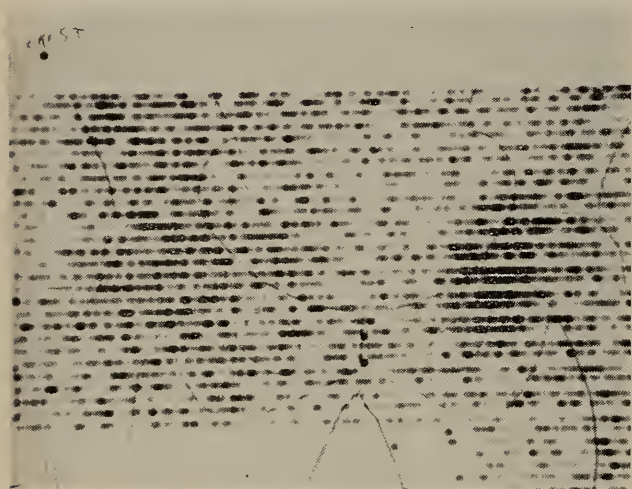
Case IV. Bone scan of pelvis that had negative x-ray examination showing lesion in left acetabular region.
